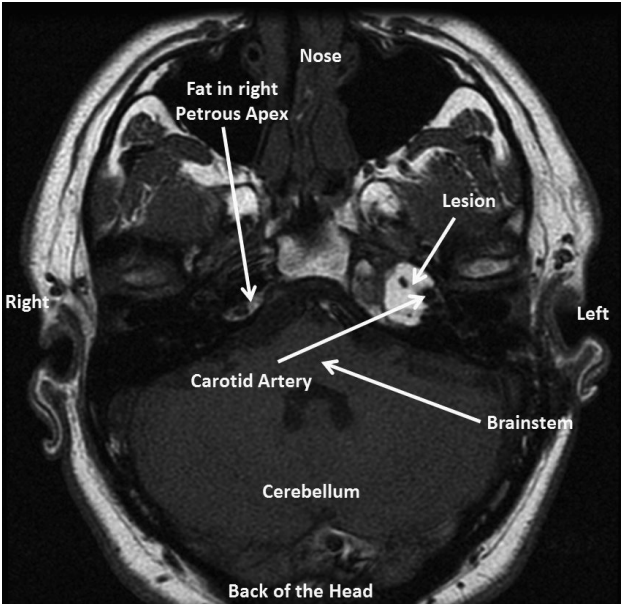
Axial (horizontal) T1 MRI of the brain, demonstrating a large mass in the left petrous apex that is brighter than the surrounding brain. The mass engulfs the anterior half of the carotid artery.
